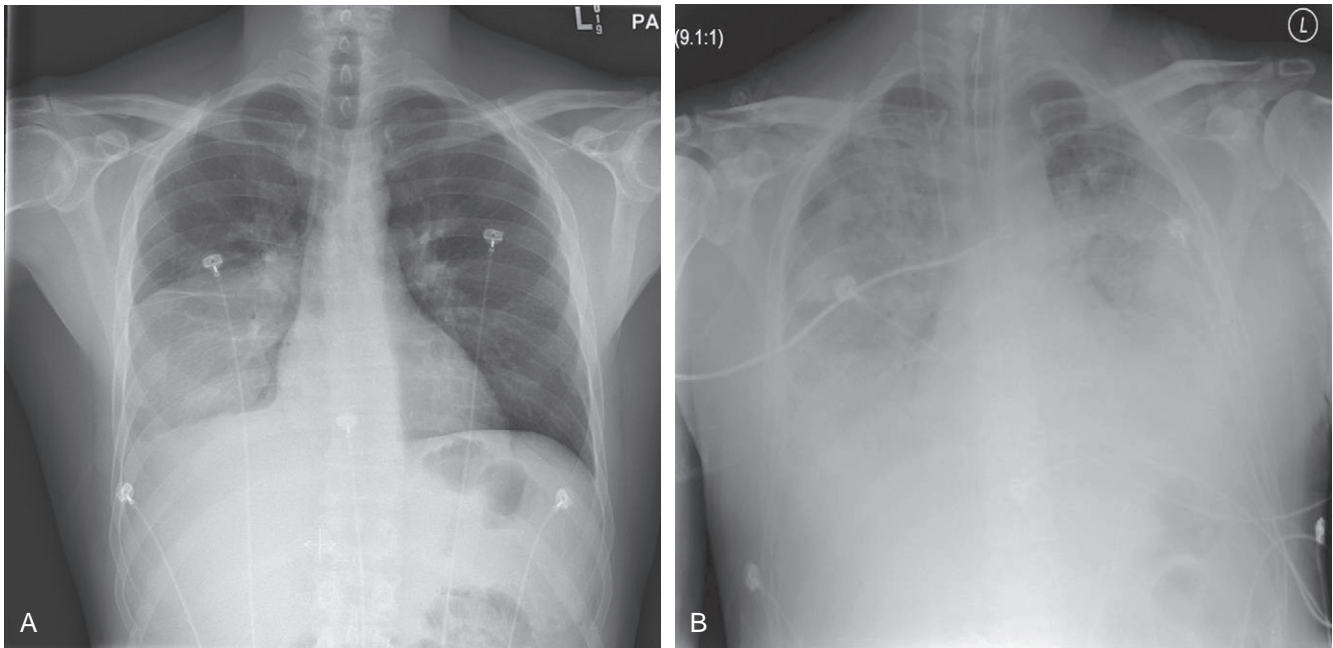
A, Chest radiograph at time of admission. B, Chest radiograph at time of intubation.
